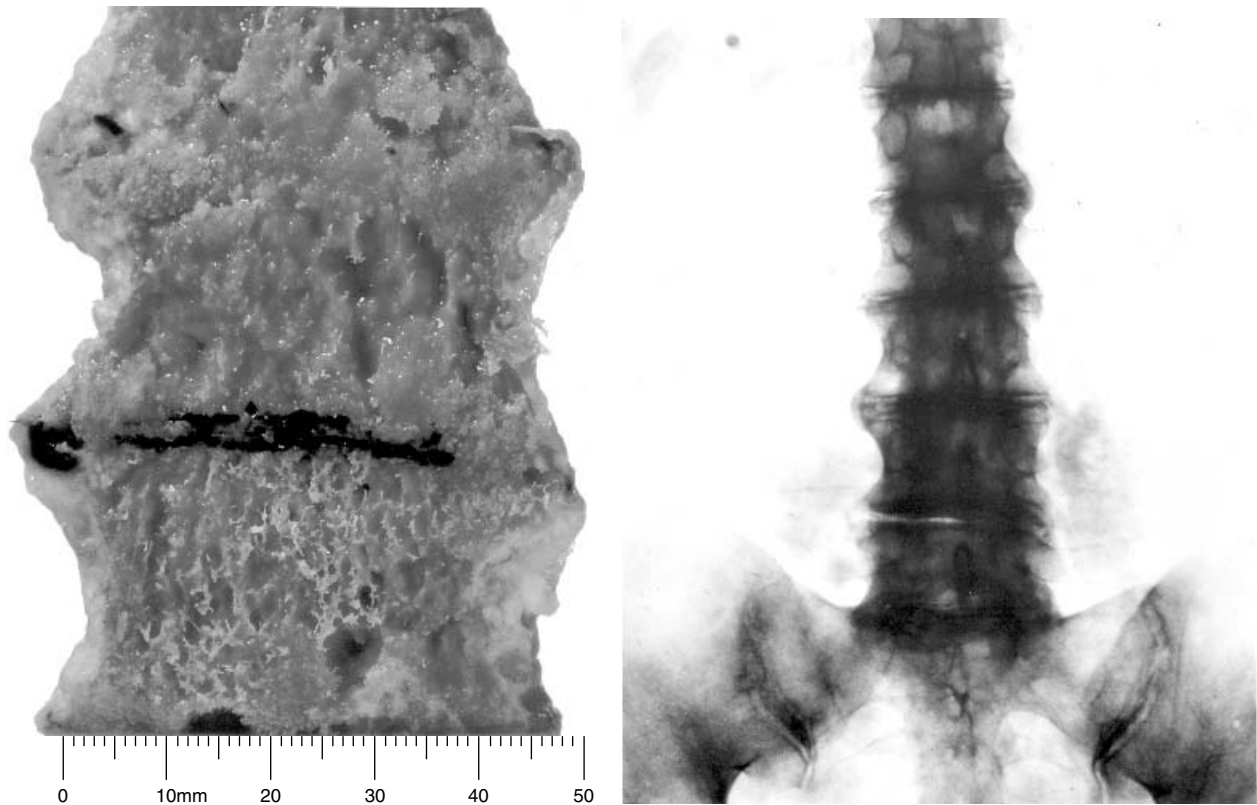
Alkaptonuric spines showing the typical narrowing and calcification of the intervertebral disks (Photograph on the left, see also Legend to Figure 9, courtesy of Dr. B. Bode, Department of Pathology, University Hospital, Zurich, Switzerland; radiograph on the right, from Bunim et al [38]).
